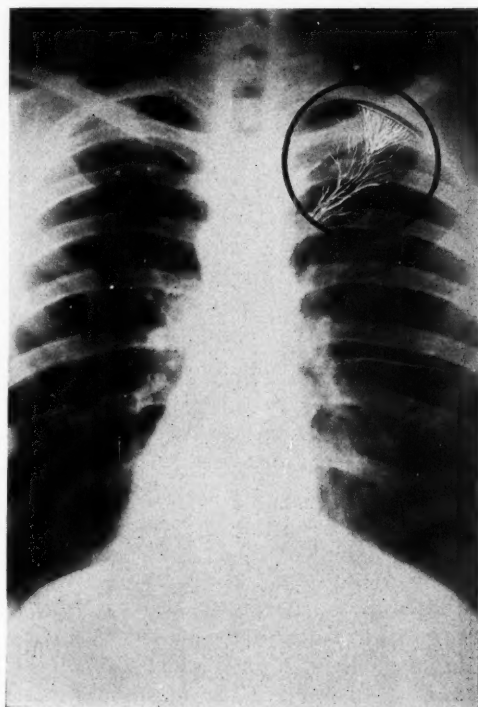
Radiograph (retouched) showing earliest evidence of tuberculous lesion in lung. Note accentuation of the peribronchovascular markings extending toward hilum from lymph drainage in that direction (Dunham's fan). Note pleural thickening over area involved, due to drainage toward pleura. Note thickening of the interlobar pleura, shortest pleural route of infection to hilum.
